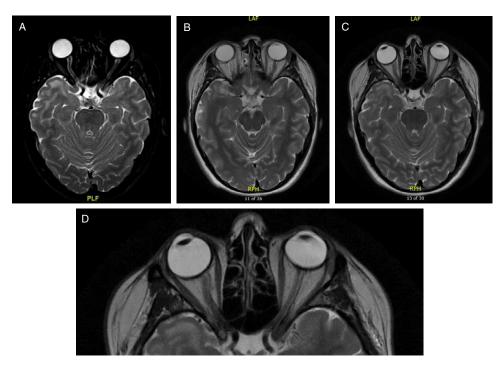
(A) Day 4, axial T2 MRI: No significant abnormality noted within the orbits, but extensive bilateral abnormal T2 hyperintensity in the white matter of the anterior temporal poles. No abnormal contrast enhancement is identified (not shown). (B) Day 16, axial T2 MRI: Abnormal subcortical white matter signal in the temporal poles, right more than left with mild fullness, with subtle focal enhancement on the right (not shown). Mild thickening and increased T2 signal in the left ON in the orbit. Somewhat oblique cut of the slice explains why the right ON appears obscured. (C and D) Eight-month follow-up, axial T2 MRI: Stable to minimally decreased extent of signal abnormality in the subcortical white matter of the anterior temporal lobes, more so on the right. Atrophic left ON with subtle associated signal abnormality. Abbreviations: MRI – magnetic resonance imaging, ON – optic nerve.
